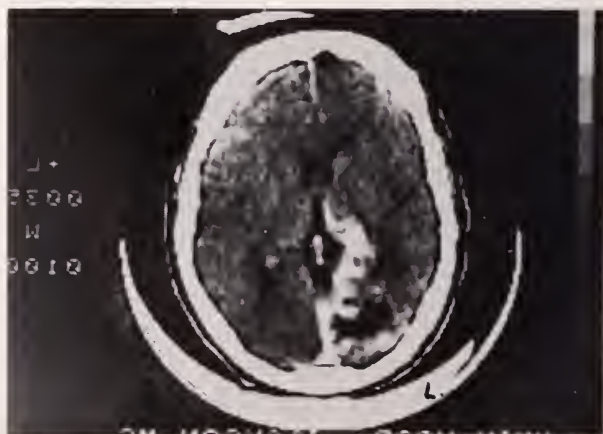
Post contrast CT scan, Case 1.
